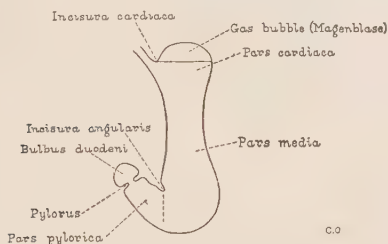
Fish-hook stomach. The usual vertical type, indicating the parts shown by the roentgenogram (Carman).
